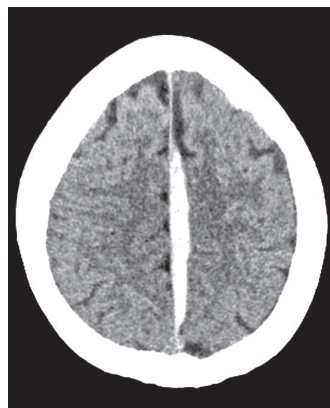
Brain computed tomography – subdural haematoma along the falx cerebri
